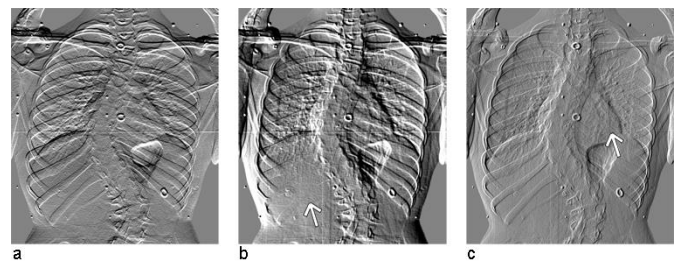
Embossed image from the anisotropic filter in (2) applied to a chest radiograph of a scoliotic patient with centered grayscale ($\mu=128$). Orientation θ , contrast γ and depth δ are all controllable parameters. Shown here are (a) $\theta = 90^\circ$, $\gamma = 5$, $\delta = 3$; (b) $\theta = 40^\circ$, $\gamma = 6$, $\delta = 5$; (c) $\theta = 336^\circ$, $\gamma = 1$, $\delta = 2$. The white arrows point out zones where ribs have almost completely disappeared.
